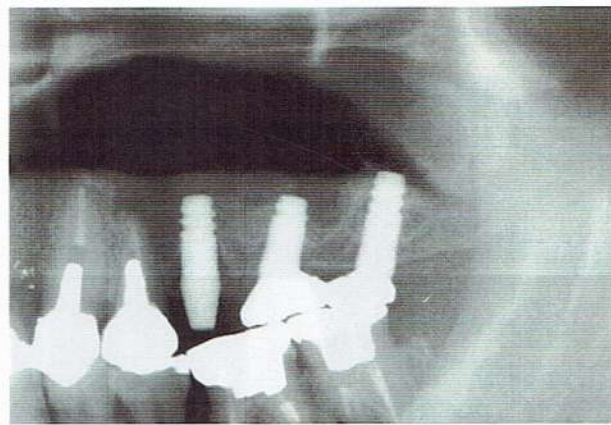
Radiograph at 1-year follow up showing new bone formation on left first molar
